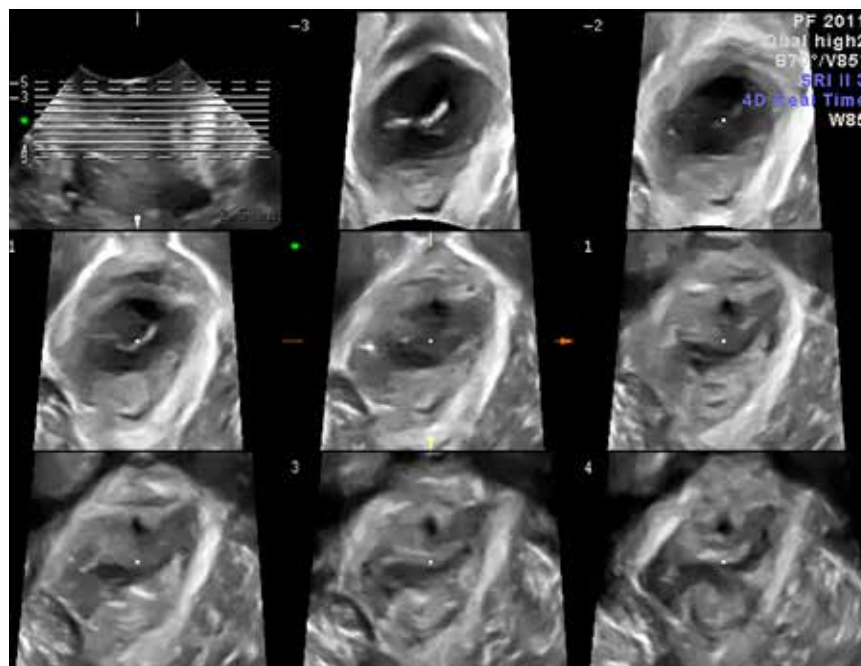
3D/4D perineal ultrasound demonstrating right-sided levator muscle avulsion. Courtesy of Professor HP Dietz, Sydney.
